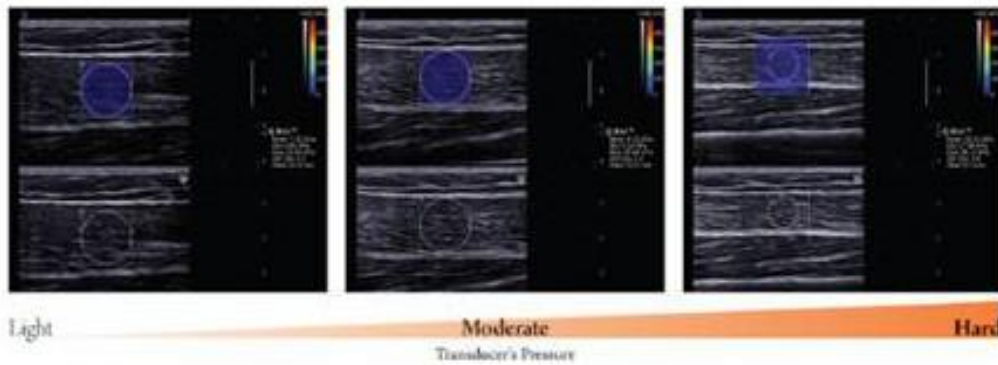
Longitudinal sonograms of rectus femoris (RF) taken with different transducer's pressure. Upper images show color-coded box presentations of RF elasticity (stiffer areas were coded in red and softer areas in blue) superimposed on a longitudinal grey scale sonogram of RF, with the circle representing the region of interest and its corresponding elastic modulus demonstrating under Q-Box™ on the right. Bottom images show longitudinal grey scale sonograms of RF on the identical scan planes. Transducer' pressure changed gradually from light to hard. The transducer was kept motionless for 8 to 12 seconds during the acquisition of the SWUE sonogram and ROI of 15 mm diameter was used. doi:10.1371/journal.pone.0044348.g001
